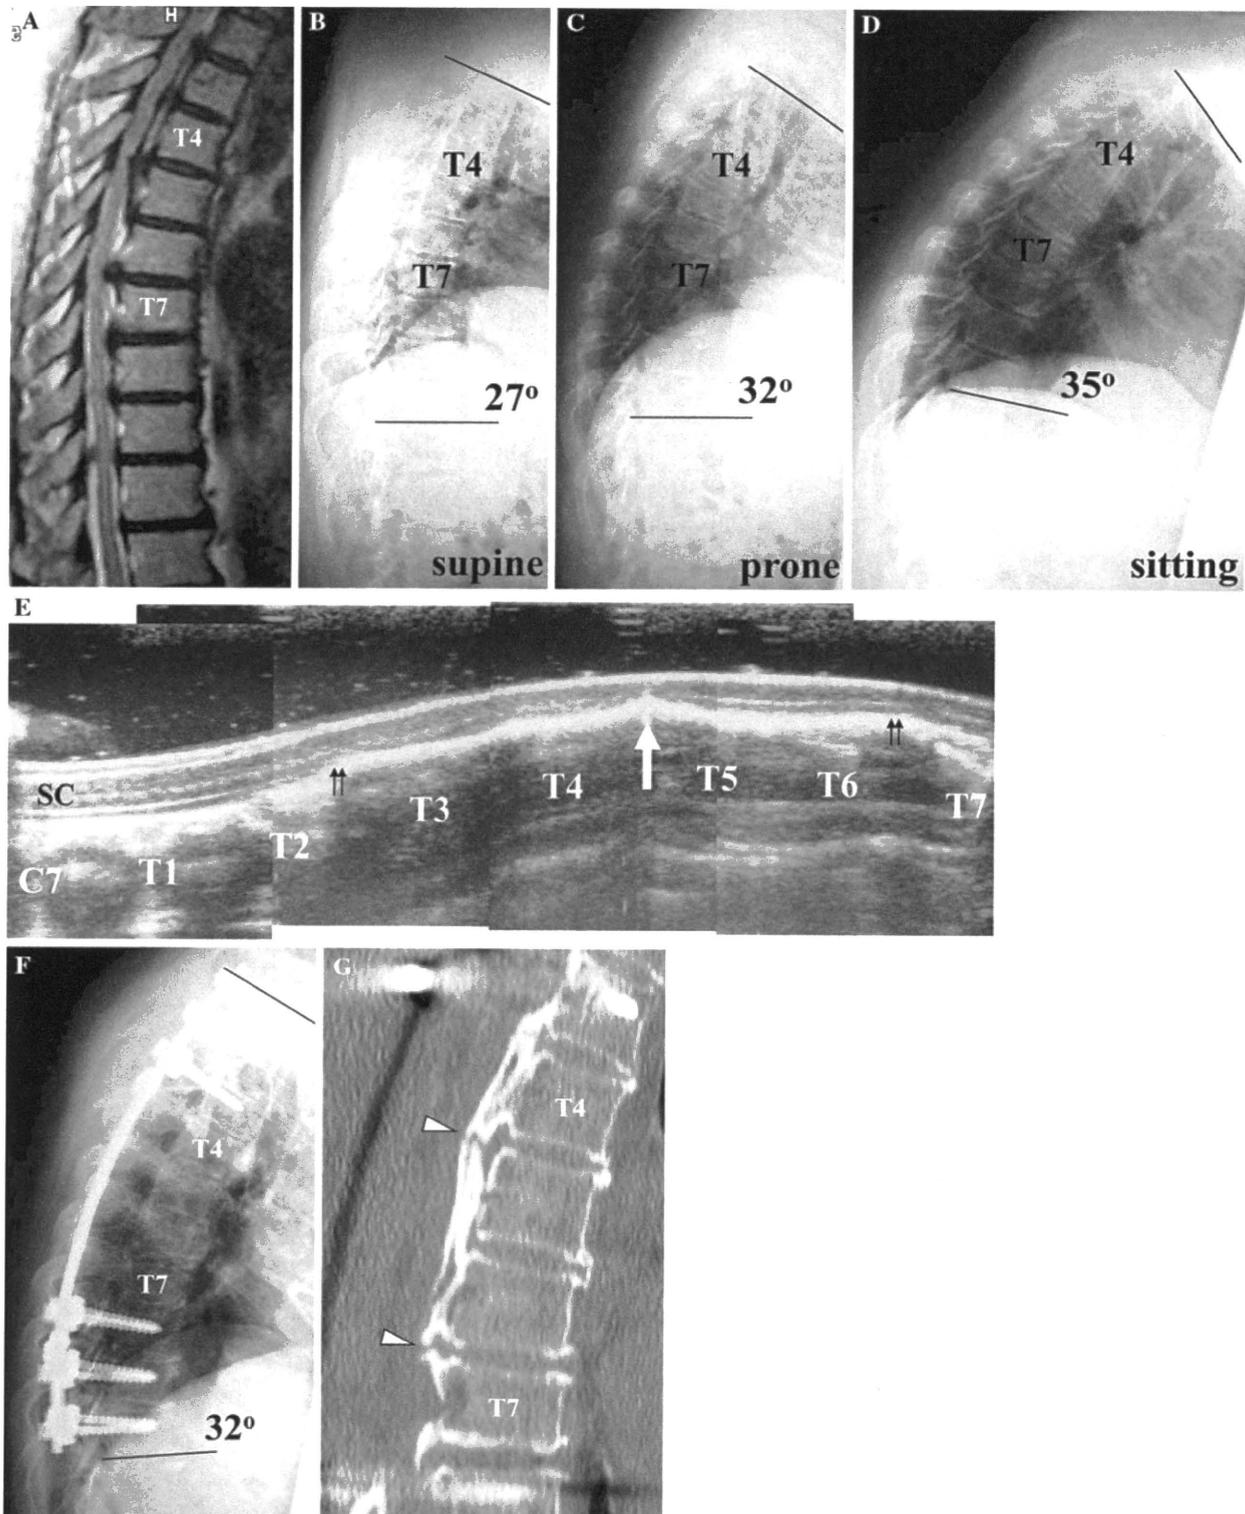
Preoperative T2-weighted MR image at the midsagittal plane (a) of a 55-year-old woman (Case 20), showing severe narrowing of the spinal cord at T4/5 and T6/7. Preoperative radiographic images show that the kyphotic angle at T1–T10 was 27° in the supine position (b), 32° in the prone position (c) and 35° in the sitting position (d). Intraoperative spinal ultrasonography at the midsagittal plane after laminectomy shows anterior impingement of the spinal cord by a
